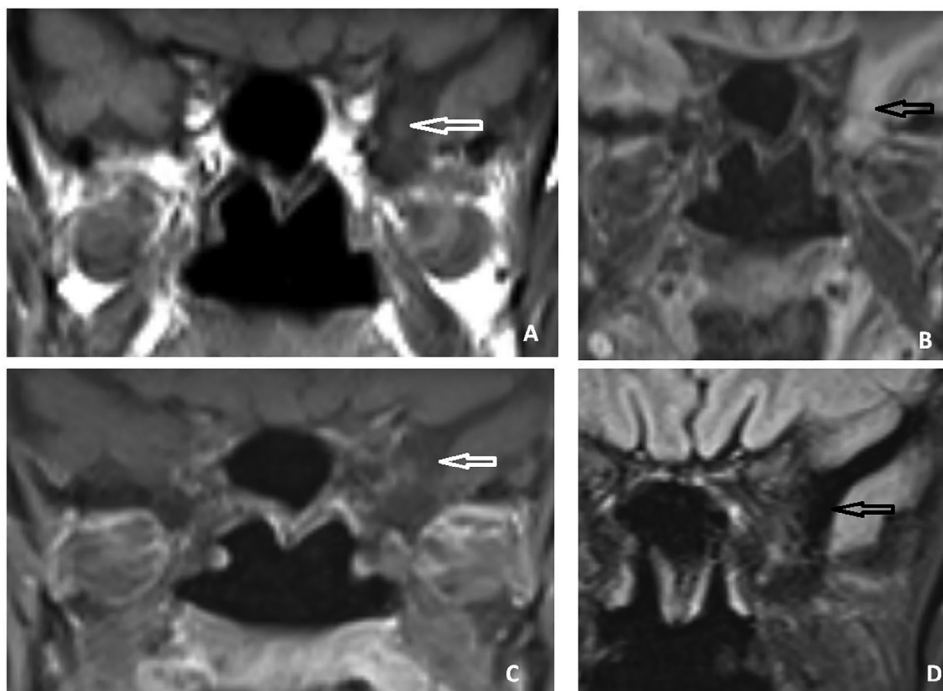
Magnetic resonance images of the skull base. Coronal T1-weighted (A) and coronal postcontrast fat saturation (C) confirm the lesion as nonenhancing (arrows). Coronal T2-fluid-attenuated inversion recovery (B) shows high signal and coronal fluid-attenuated inversion recovery (D) shows the suppression of T2 high signal (arrows) within the lesion.
